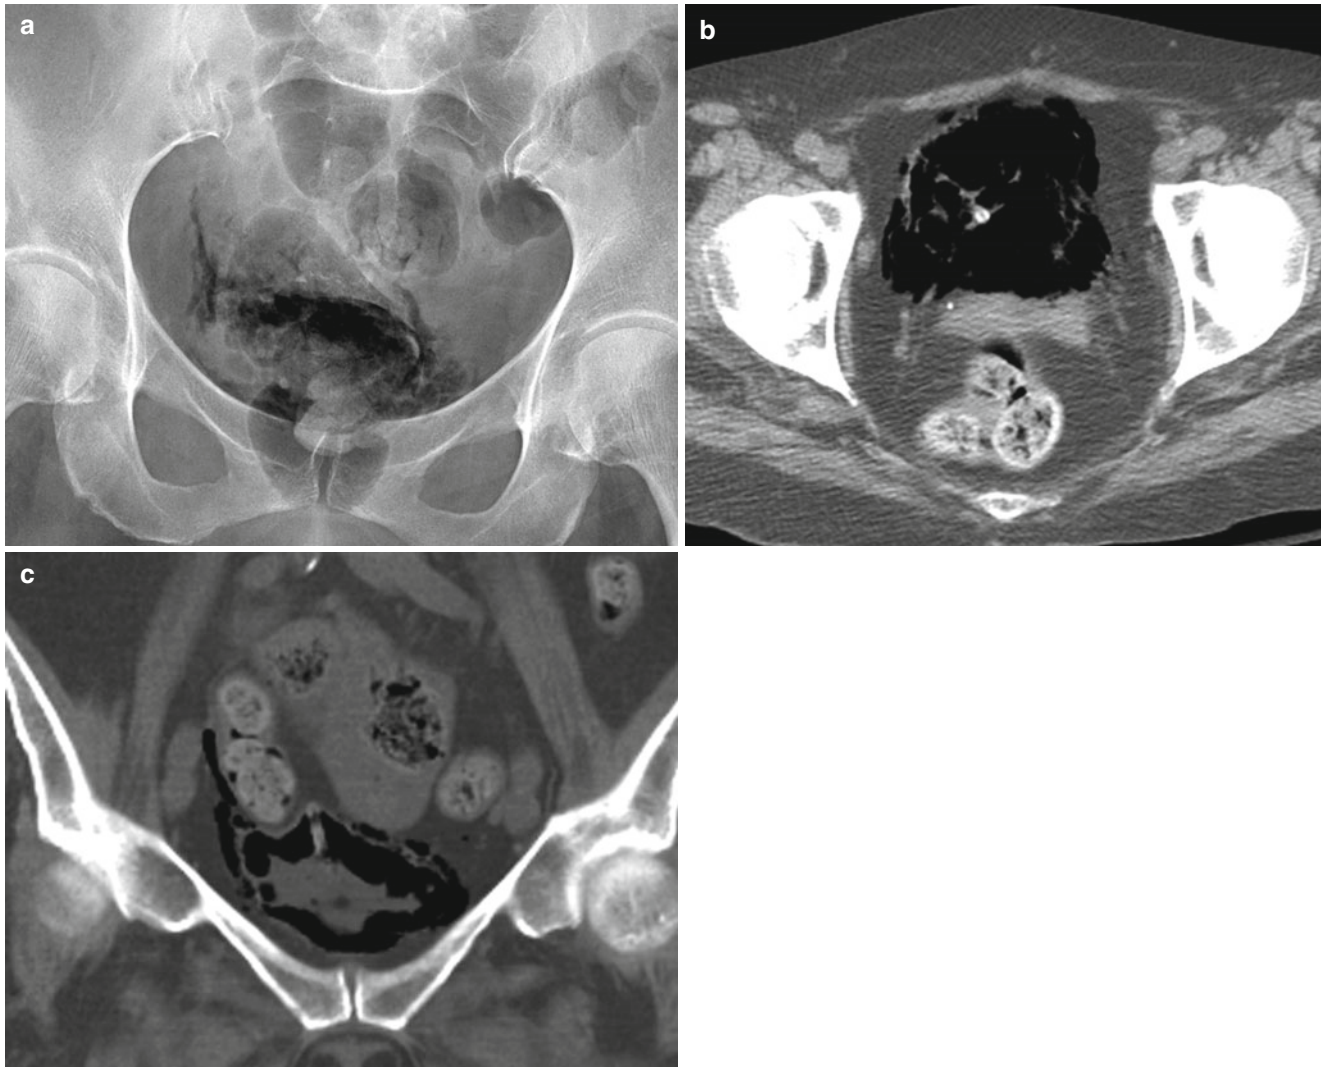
Emphysematous cystitis in a 62-year-old female with right flank pain and UTI. (a) Pelvis radiograph shows pelvic lucencies consistent with bladder gas as confirmed on CT. (b) and (c) CT images
